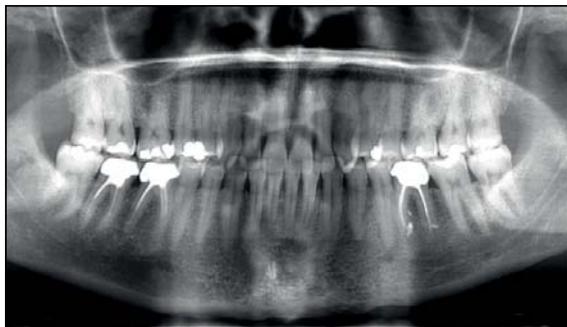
Orthopantomogram one year of evolution.
